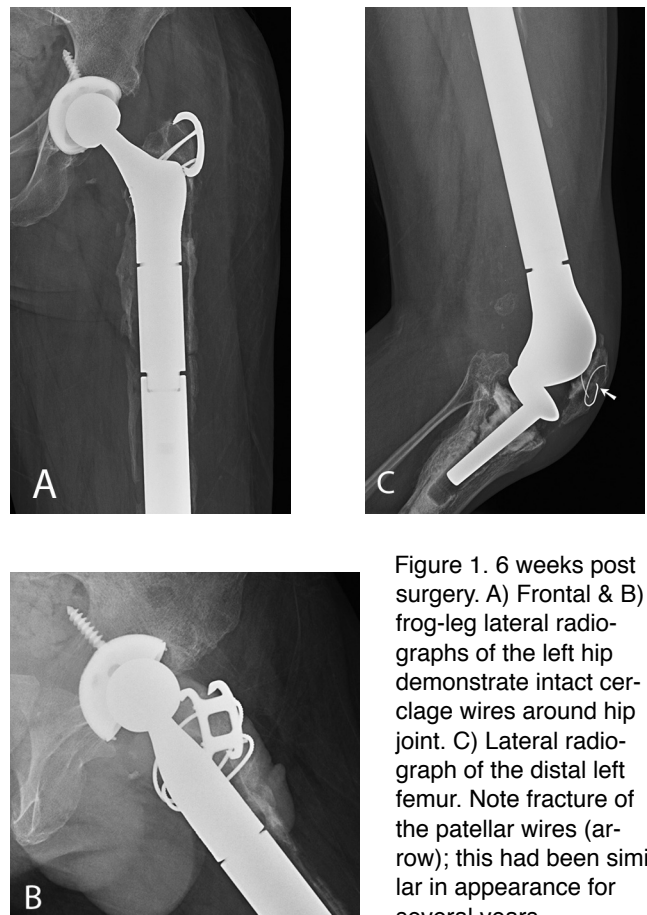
6 weeks post surgery. A) Frontal & B) frog-leg lateral radiographs of the left hip demonstrate intact cerclage wires around hip joint. C) Lateral radiograph of the distal left femur. Note fracture of the patellar wires (arrow); this had been similar in appearance for several years.
